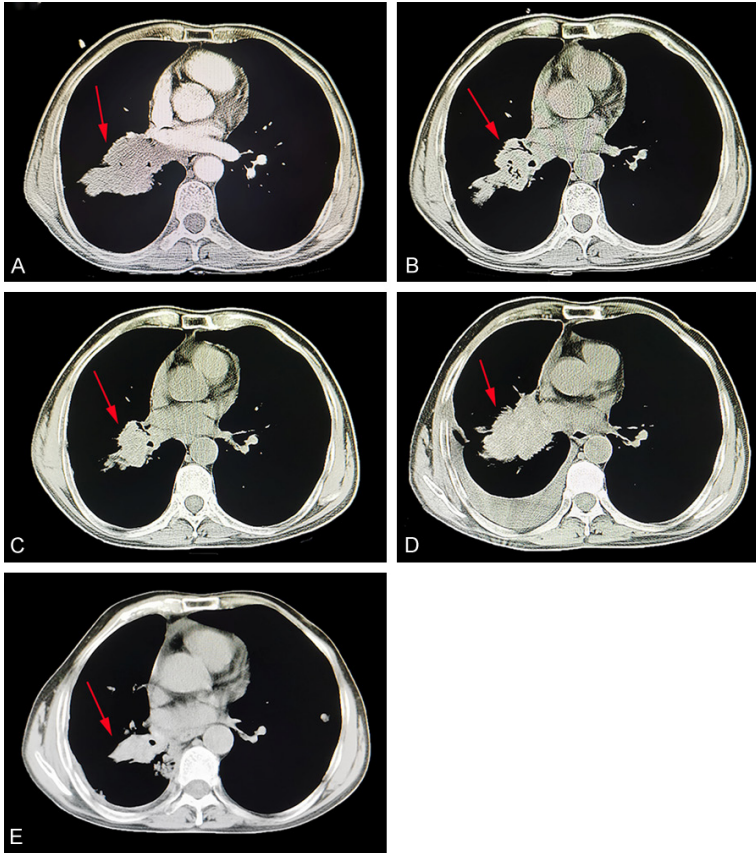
Chest CT at different times of treatment in a typical case of lung squamous cell carcinoma patient. A. A 96 mm * 58 mm tumor in the right hilum of the lung grew across the oblique fissure toward the lower lobe. B. After treatment with docetaxel plus cisplatin for 2 months, the tumor in the right hilum was significantly reduced, with a size of 63 mm * 38 mm. C. Maintaining the original chemotherapy regimen for 2 month, the Hilum tumor shrank again. D. The patient was admitted to hospital again after discharge. Chest CT showed that the tumor was enlarged with a small amount of pleural effusion. E. After radiotherapy combined with thoracic perfusion chemotherapy, the tumor shrank again and pleural effusion reduced.
